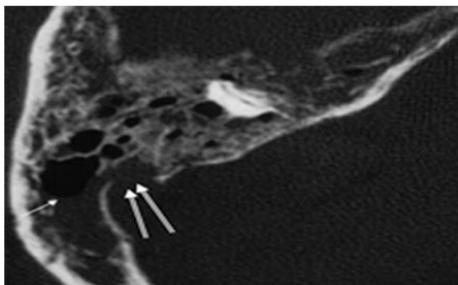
Acute coalescent mastoiditis. Right temporal CT scan axial section showed extensive mastoid debris with air fluid level (arrow). All septa are thin and irregular. There is also a sigmoid sinus defect (double arrow) which in the reading reveals a suspicion
